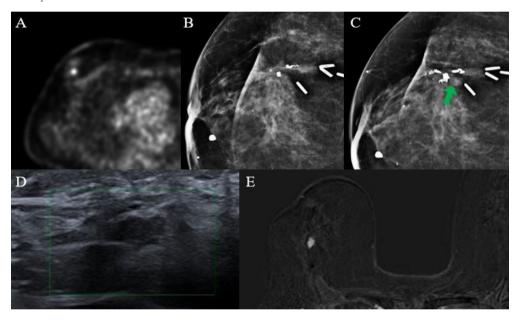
A local recurrence in a 58-year-old woman with a history of mucinous carcinoma (A) Abnormal FDG-uptake at the operation site on PET scan (B) Postoperative changes on the right CC view that examined in 2018 and followed by consecutive PET scans (C-E) But also visible on MG, US and MRI
